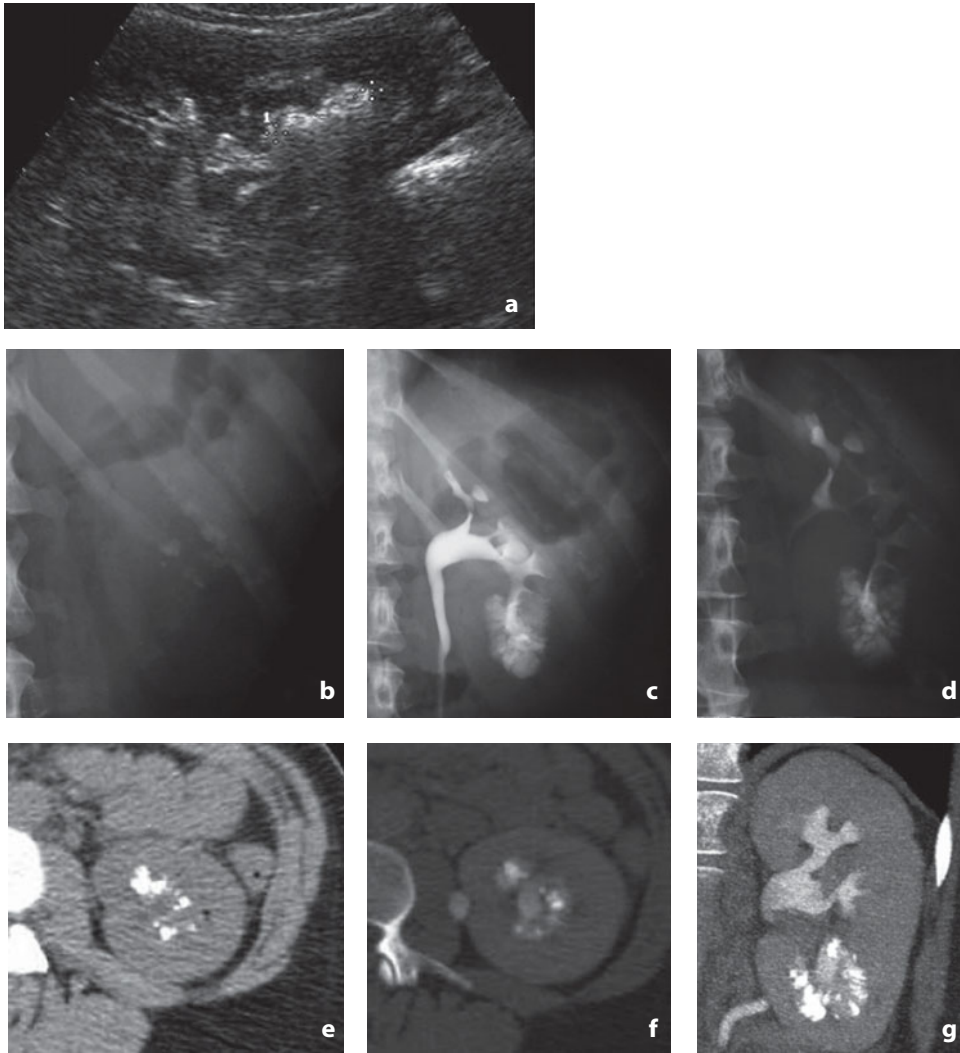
Ultrasonography, urography and CT. Sponge kidney. a Sonogram shows a hyperechoic image with posterior acoustic shadowing and lithiasic appearance at the level of the inferior sinus of the left kidney. b Plain abdominal film shows minute spotty calcifications in the lower pole of the kidney. c At urography multiple papillary streaks and pools of contrast medium distal to the inferior minor calices typical of sponge kidney. d Similar appearance in nephrotomography. Of note is the regular morphology of the caliceal fornices. e Nonenhanced CT confirms the presence of calcifications. f,g Successive low-dose CT urography shows the position of the calcifications outside the pelvicalyceal cavity
